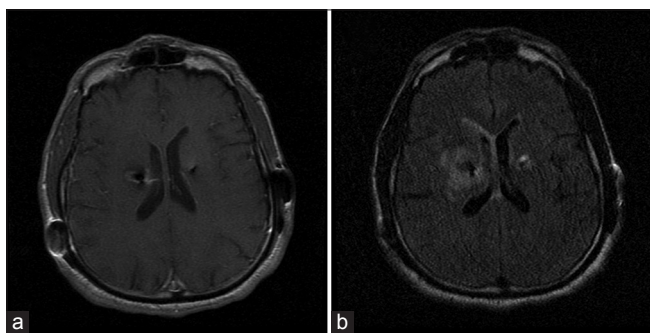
Magnetic resonance imaging T1 with contrast (a) and fluid attenuated inversion recovery (b) sequences for patient 1
